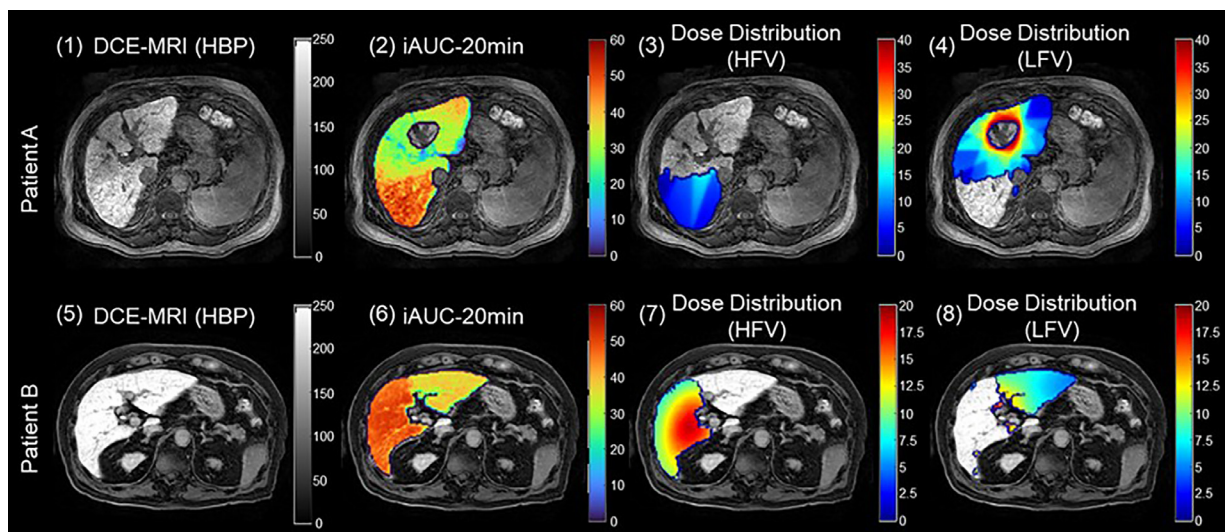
From left to right: contrast-enhanced magnetic resonance imaging (MRI) at hepatobiliary phase (HBP), color-coded initial area under curve (iAUC)-20 min maps, dose distribution in high function volume (HFV), and dose distribution in low function volume (LFV) in 2 participants with hepatocellular carcinoma (HCC) treated with stereotactic body radiation therapy (SBRT). Color scale indicated the magnitude of iAUC-20 min (unitless) or dose (Gy), with blue representing lower magnitudes and red representing higher magnitudes. (A) Patient A with improved liver function after SBRT. (B) Patient B with deteriorated liver function after SBRT. *Abbreviation:* DCE-MRI = dynamic contrast-enhanced magnetic resonance imaging.
